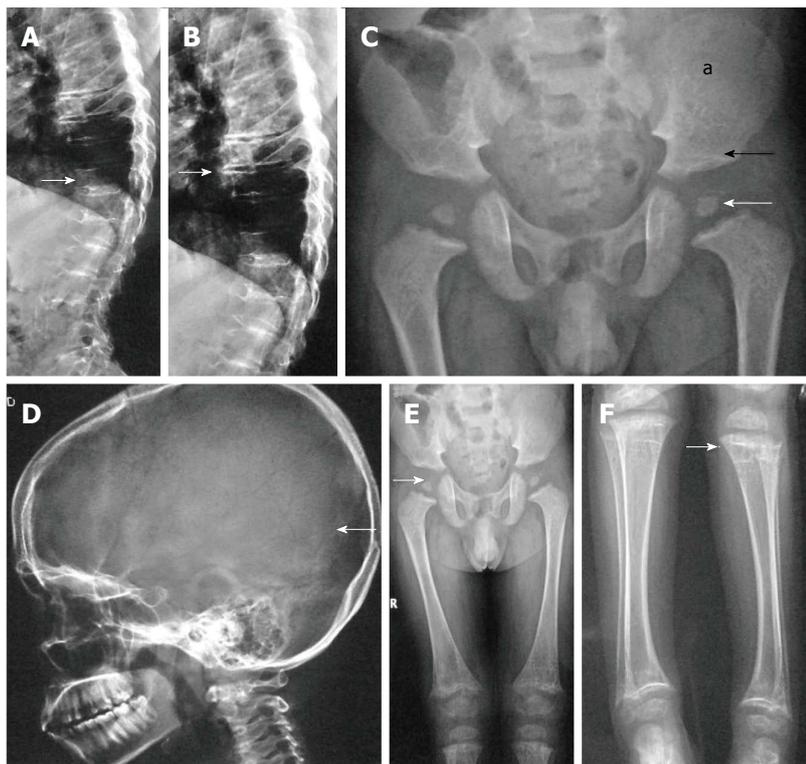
Spondyloepiphyseal dysplasia congenita. Lateral radiographs of dorsolumbar spine show platyspondyly (arrow, A) with severely reduced intervertebral disc spaces (arrow, B). Radiograph of pelvis (C) shows small femoral epiphyses (white arrow), horizontal acetabuli (black arrow) and short iliac wings (a). Radiograph of skull (D) shows relatively enlarged calvarium (arrow). Radiographs of lower limbs (E, F) show relatively short femurs and small epiphyses with secondary metaphyseal irregularity (arrow, F).
